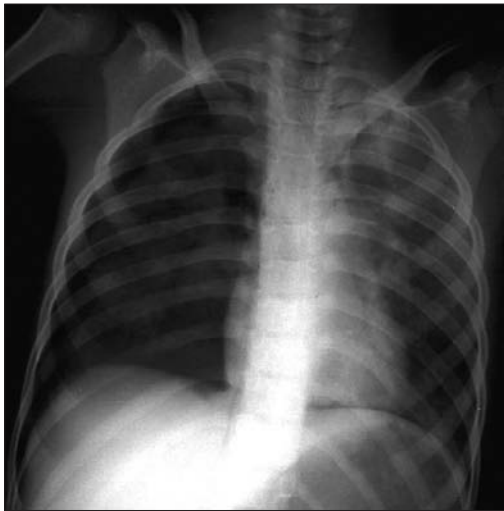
Chest radiograph obtained at presentation. Diaphragm contour is clearly seen on the right. Deep right costophrenic sulcus and visceral pleura seen in the right peripheral space suggest pneumothorax. Additionally, pneumomediastinum is visible in the upper mediastinum.
